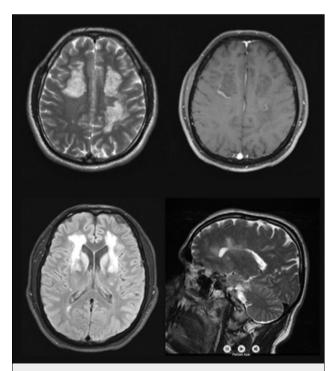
Brain MRI scan showing bilateral hyperdense confluent lesion involving periventricular, subcortical white matter and basal ganglia, with mild peripheral contrast enhancement on T1-weighted imaging.
